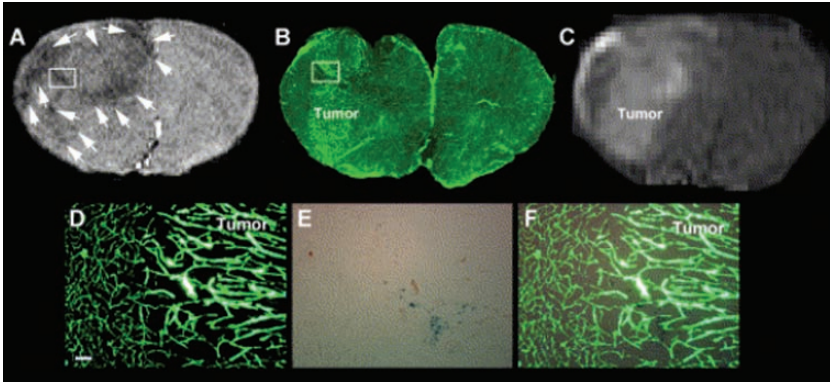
Transplanted superparamagnetic particle-labeled MSCs target brain tumor. A coronal section of three-dimensional gradient echo image shows loss of MRI signals around and within the tumor (A, arrows). Panel B shows enlarged cerebral vessels in the tumor, which matches the outline of tumor on 3D gradient echo image (A) and the extent of the tumor on Gd-DTPA contrast image (C, tumor). Panels D–F are high magnification of the box area in panel B, which matches the box area of panel A. Panels D and E show enlarged abnormal tumor vessels along with adjacent relatively normal cerebral vessels and Prussian blue-positive cells, respectively. Panel F is a merged image of panels D and E, showing grafted superparamagnetic particle-labeled MSCs around and within the tumor, which matches signal losses observed on 3D gradient echo image (A, box). Bar = 100 μm . Reproduced from Zhang et al. (2004), copyright 2004, with permission from Elsevier.
